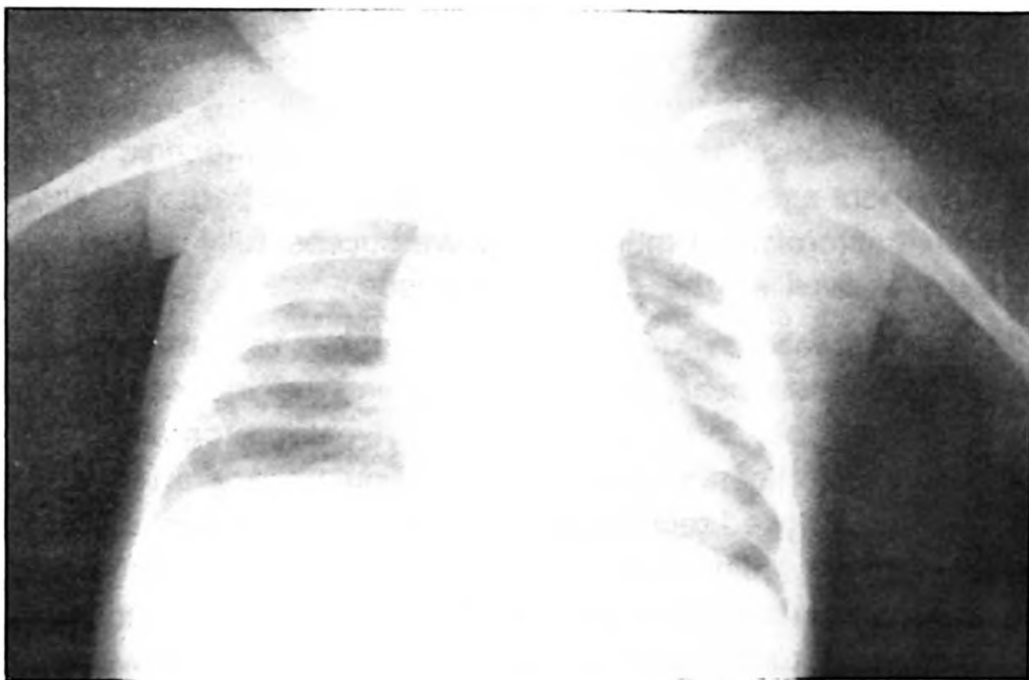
Postero-anterior chest X-ray showing the normal-sized pulmonary artery.
